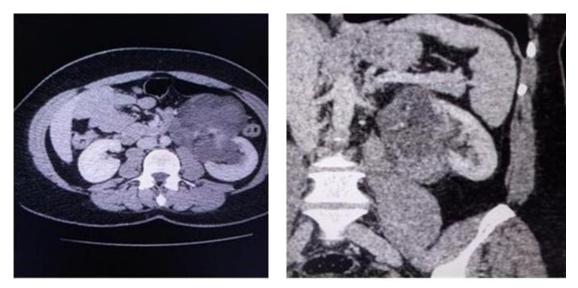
CT of 38 years female with liposarcoma infiltrated into the renal pelvis and hilum
